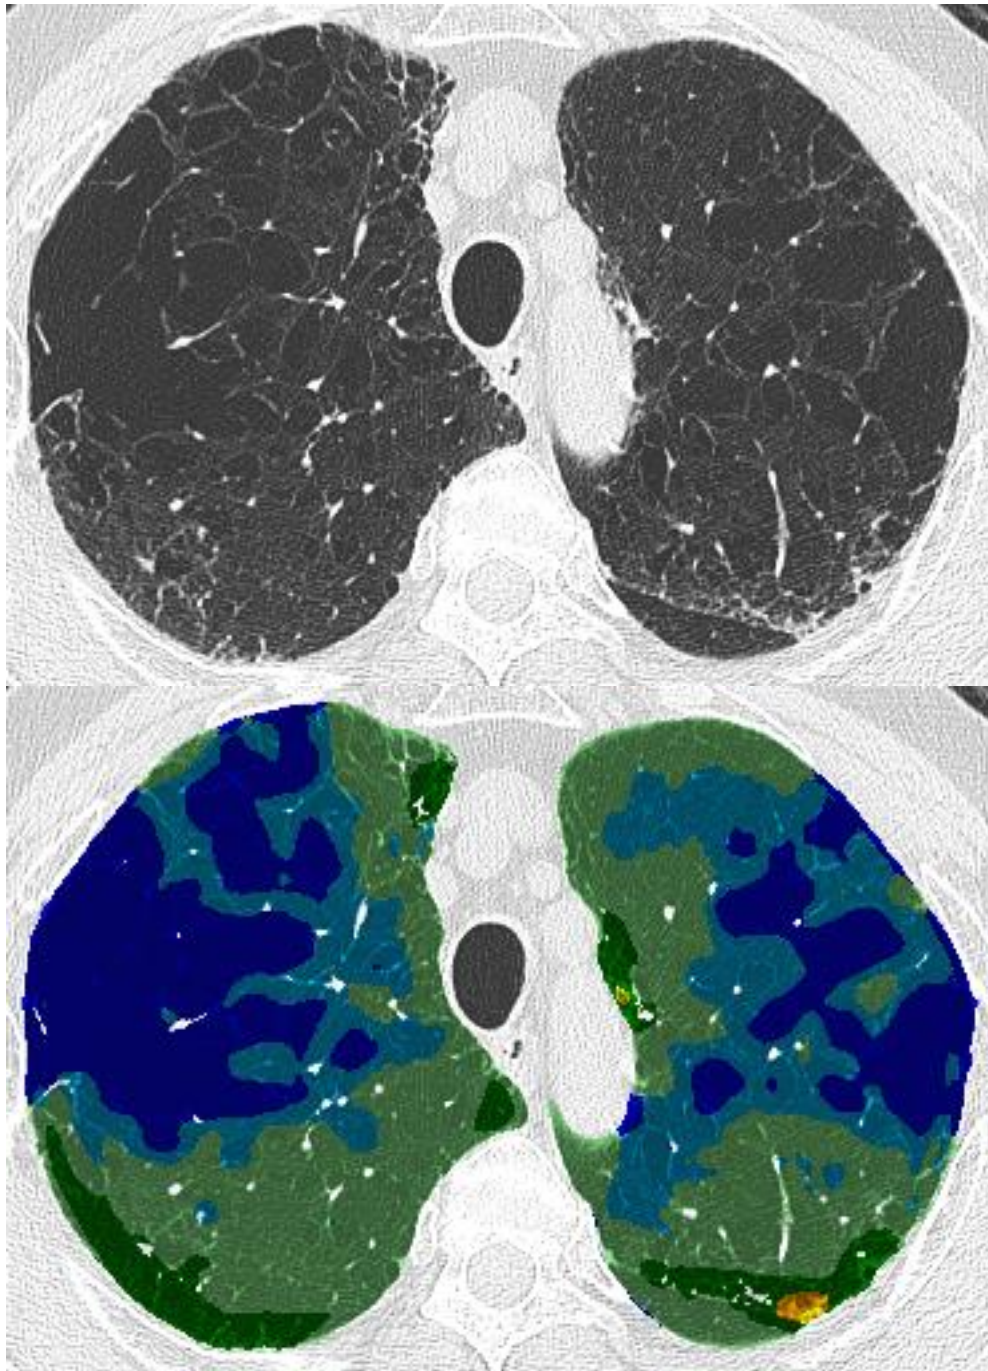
Axial CT images and colour overlay images demonstrating quantitation of parenchymal patterns by CALIPER in a 71-year-old male ex-40-pack-year smoker diagnosed with IPF. CT images (a+c) demonstrate severe emphysema in the upper lobes, and fibrosis characterized primarily by reticular pattern and traction bronchiectasis in the lower lobes, with an emphysematous bulla in the left lower lobe. On visual scoring, 40% of the lung was characterized as emphysema, whilst 31% was identified as interstitial lung disease. The CALIPER overlay images (b+d) outline emphysema (light and dark blue) in the upper lobes, quantified as 23% of the lung volume. The sum of ground glass opacities (yellow), reticular pattern (orange) and honeycombing (brown) constitute total interstitial lung disease extent which was quantified as 7.5% of the lung. CALIPER defines light and dark green areas as normal lung.
